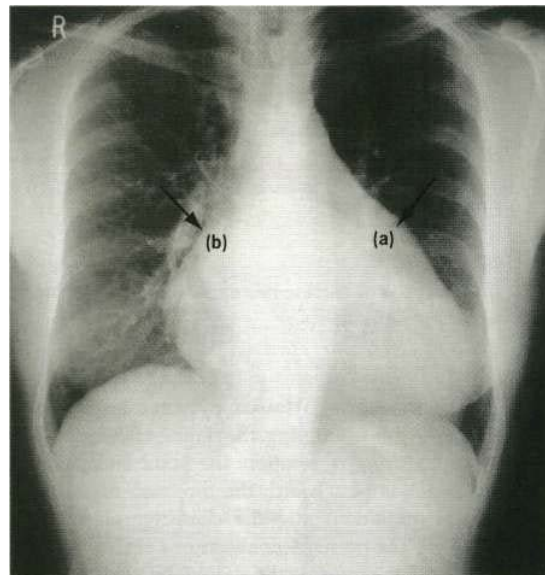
Plain PA chest X-ray of a patient with mixed mitral valve disease. The left atrium is markedly enlarged (a). Note the large bulge on the left heart border (left atrium) and the 'double shadow' (border of the right and left atria) (b) on the right side of the heart. There is cardiac (left ventricular) enlargement due to mitral regurgitation.
